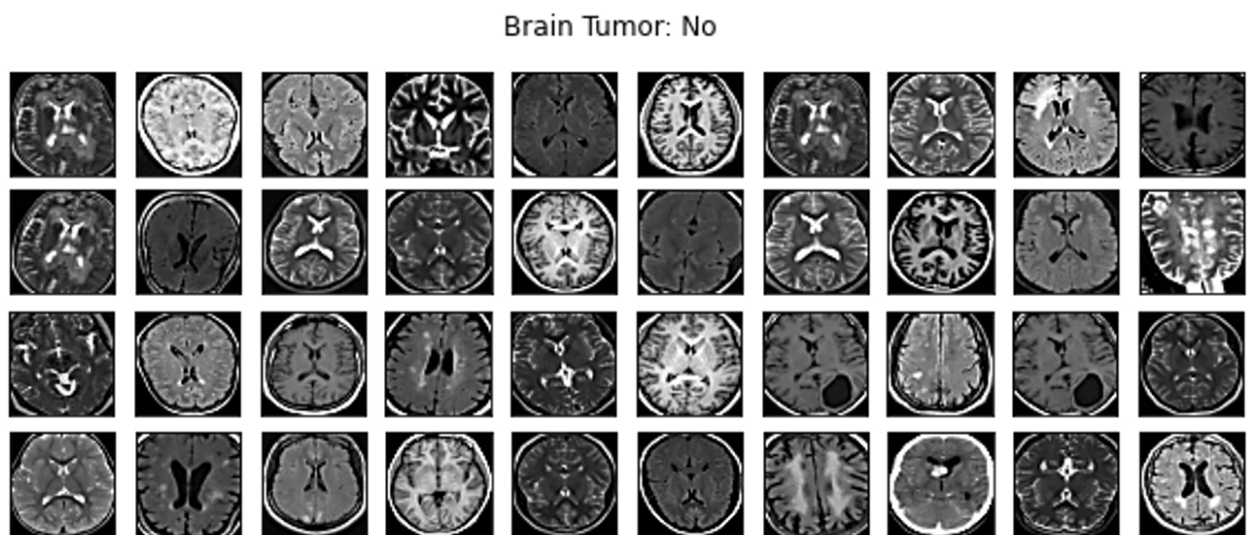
some examples of the classification results after using the Alexnet that shows normal brain MRI images
